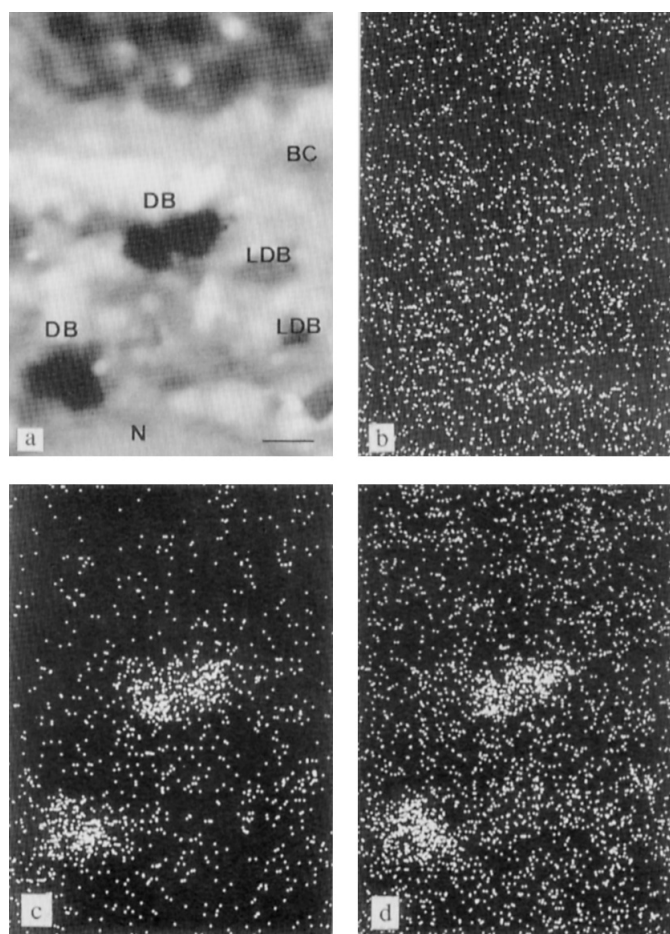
X-ray analysis of hepatocyte lysosomes before treatment of a patient with PBC.
